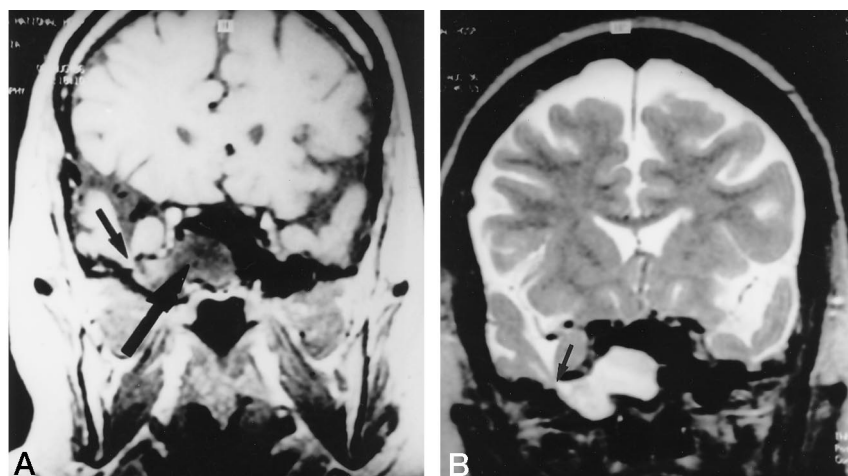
A, T1-weighted coronal MR image through the sphenoidal sinus reveals CSF fistula involving the right lateral recess of the sphenoidal sinus. Brain tissue is seen to extend into this defect (small arrow). Note the characteristic hypointense nature of the pooled CSF in the sphenoidal sinus (large arrow).
